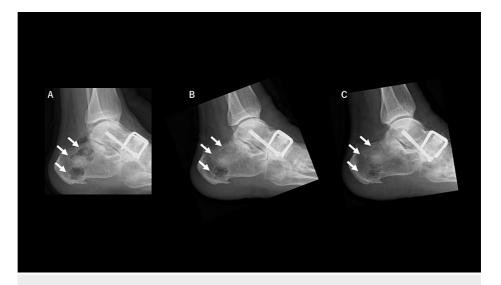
Postoperative radiograph of the foot (~14 days)
